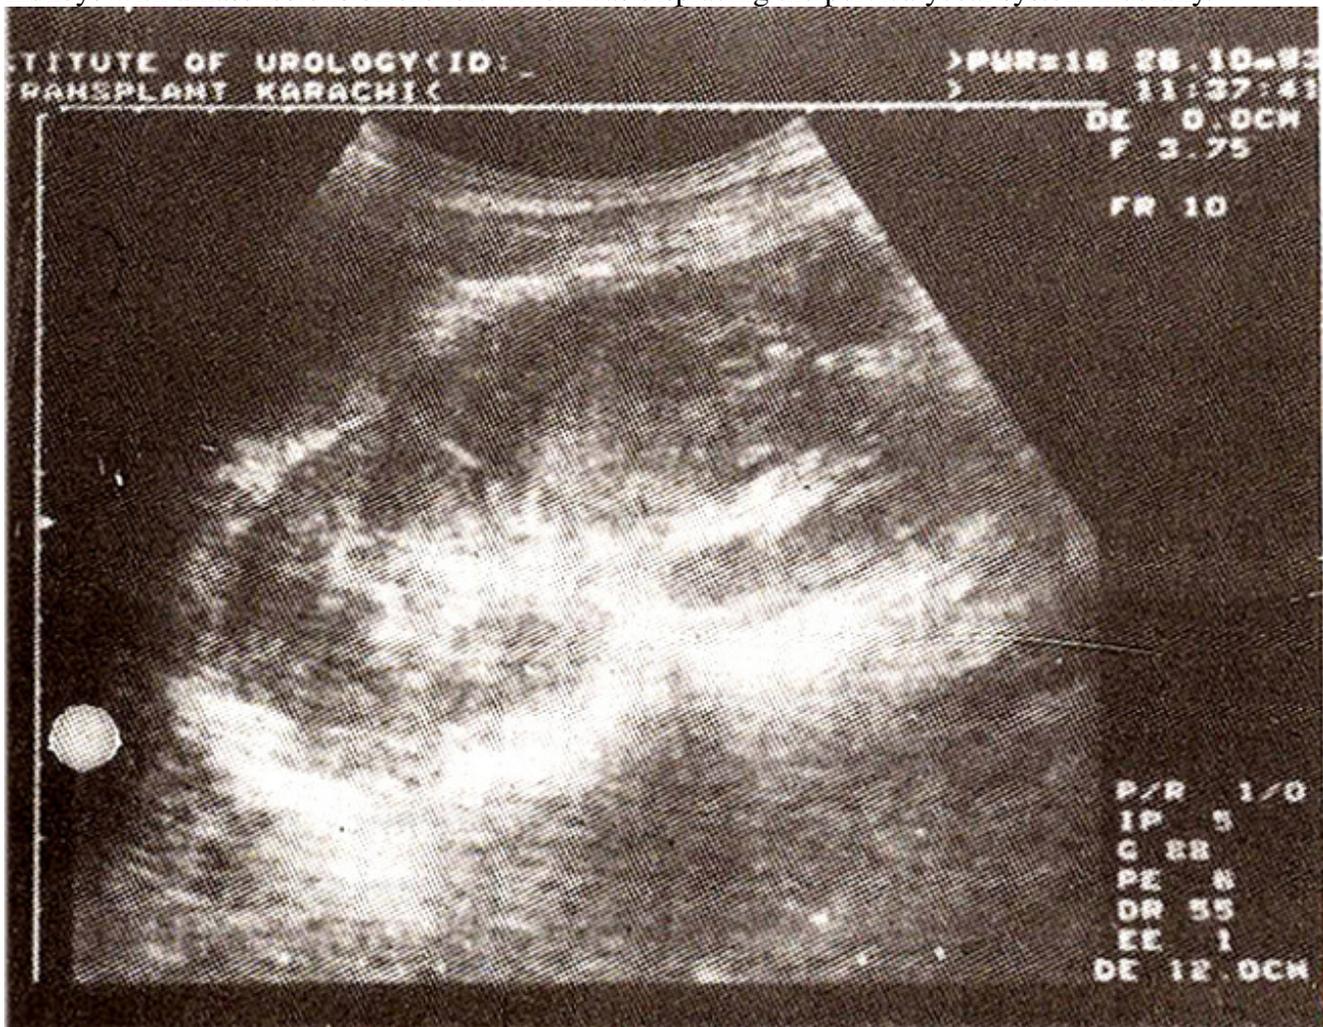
Longitudinal sonogram of the left kidney showing an altered echogenicity mass along with the outer margin causing displacement of the central echogenic complex
